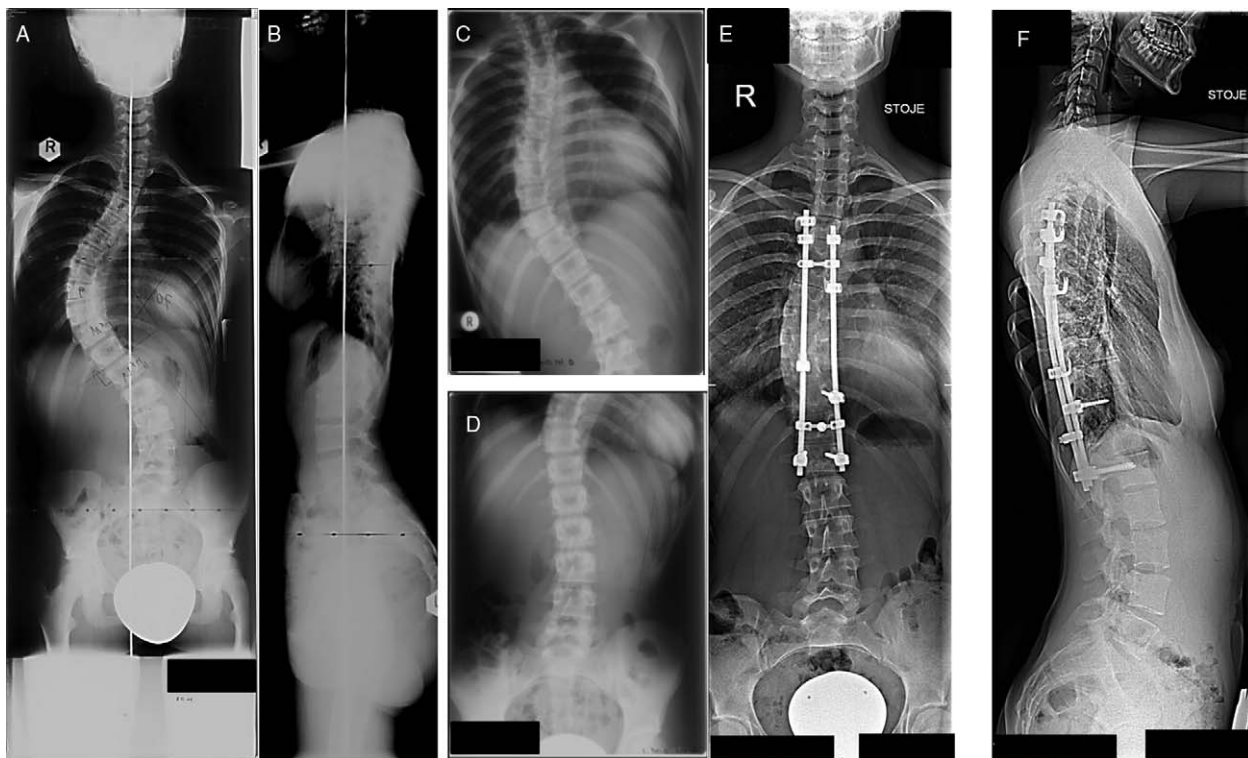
13-year-old girl with AIS. A, B, Preoperative Lenke type 1AN. C, Right side bending radiograph. D, Left side bending radiograph. E, F, Six years postoperative AP and lateral radiographs. AIS indicates adolescent idiopathic scoliosis; AP, anteroposterior.
